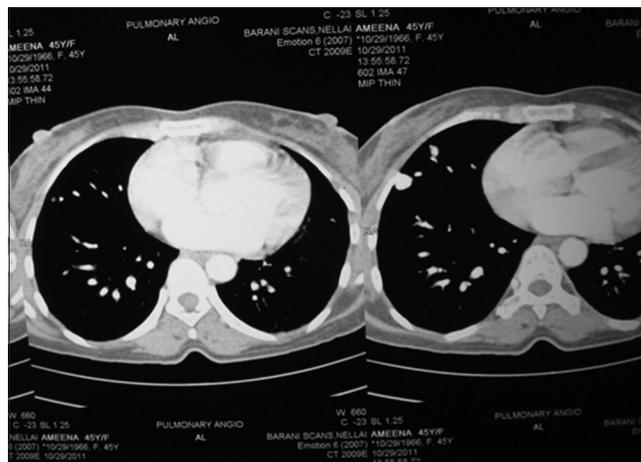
CT chest revealed- multiple lung nodules(AV malformation)
